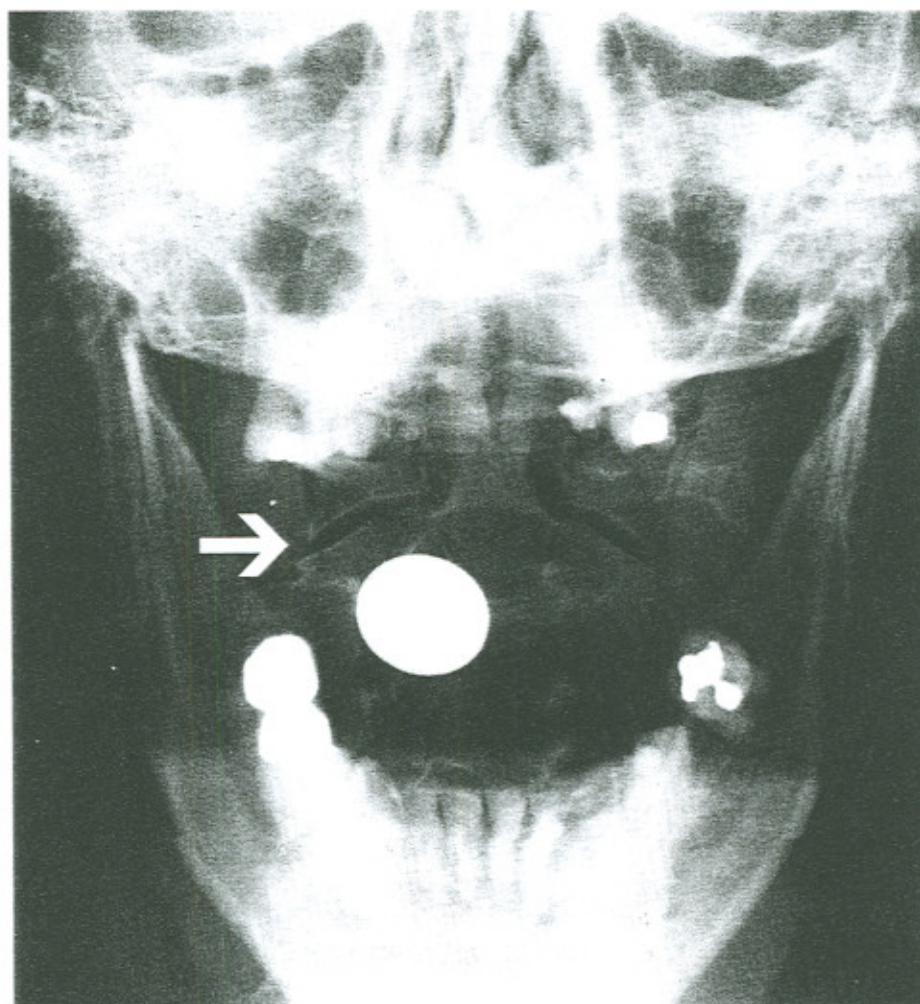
Cervical spine radiographs (same day of accident)
